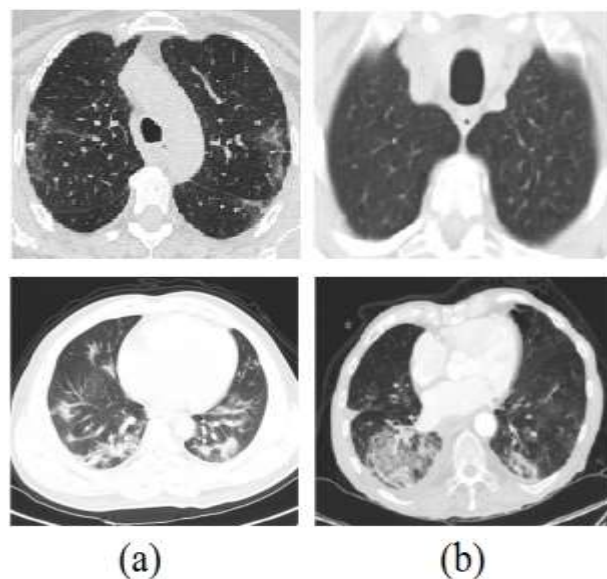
Sample CT images from the COVID-CT and SARS-CoV-2 CT-scan datasets for normal cases (a) and COVID-19 patients (b).
